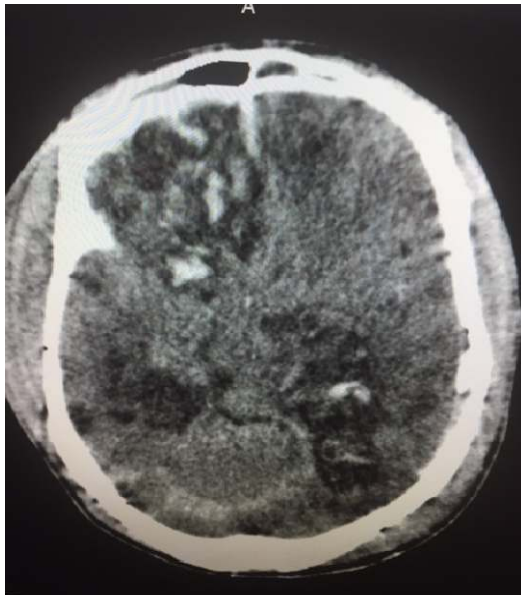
Axial CT of the brain in brain window showing multiple patchy Hyperdensities in a background of edema suggestive of haemorrhagic contusion
